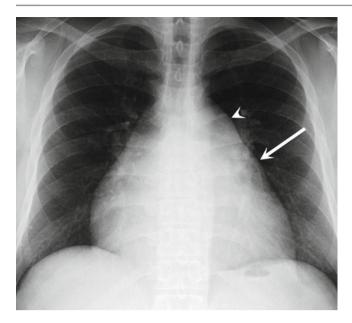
Rheumatic mitral stenosis. PA chest radiograph shows left atrial appendage enlargement (*arrow*) in keeping with rheumatic mitral stenosis. Main pulmonary artery enlargement (*arrowhead*) suggests pulmonary hypertension
